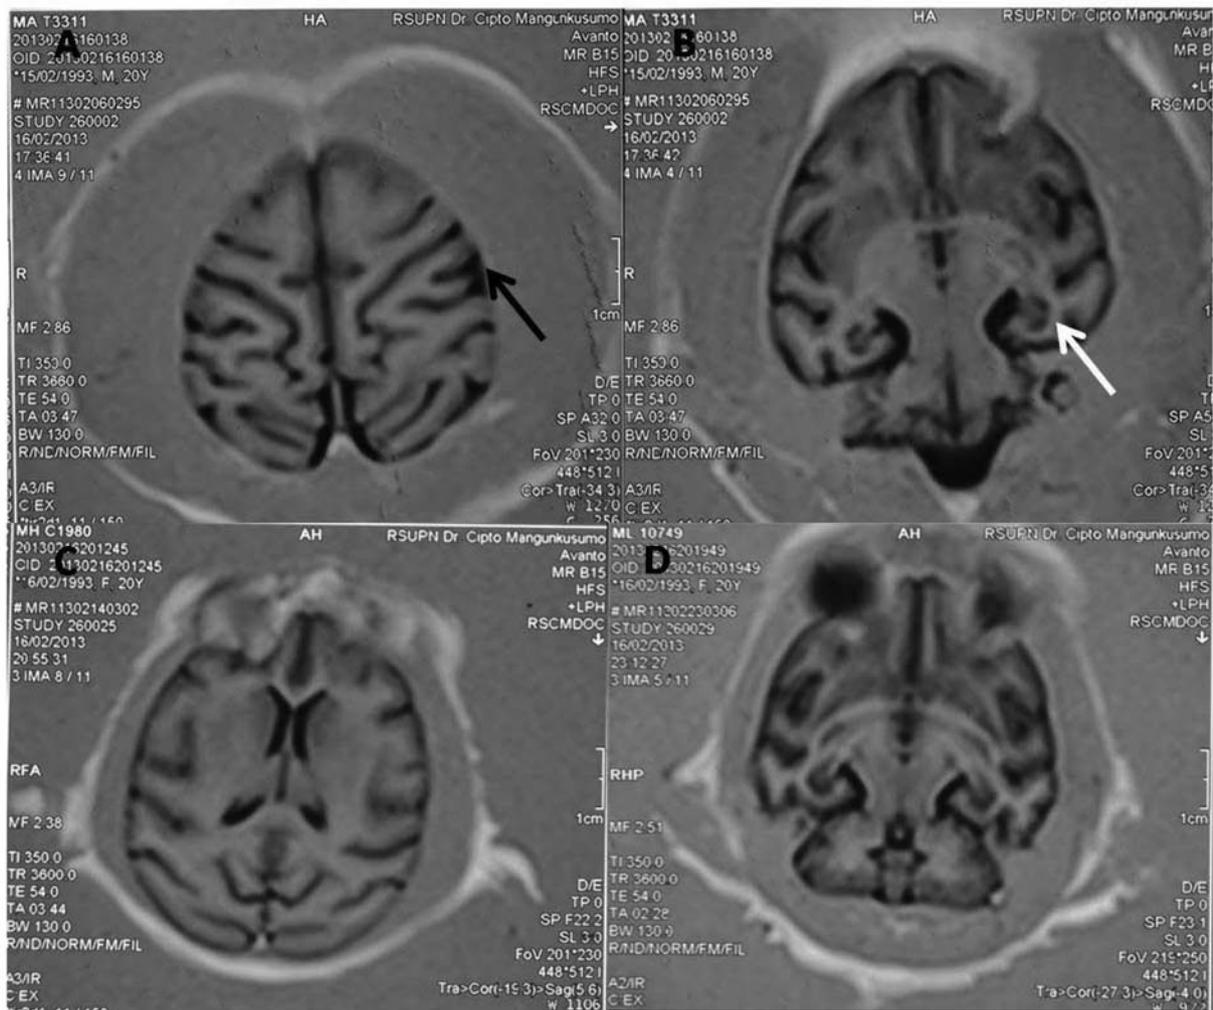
T1-weighted inversion recovery images were recorded from low performers (A and B) with indication of widening of sulci (black arrow) and hippocampal atrophy (white arrow), and high performers (C and D).
